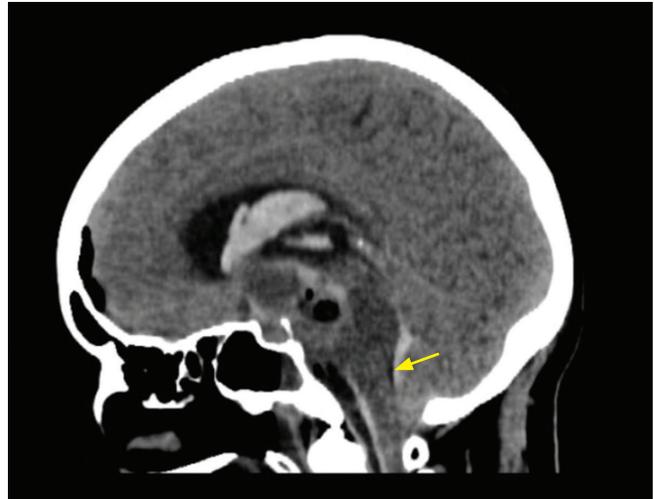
Postoperative contrast-enhanced cranial computed tomography scan showing edema (yellow arrow) of the brainstem.
